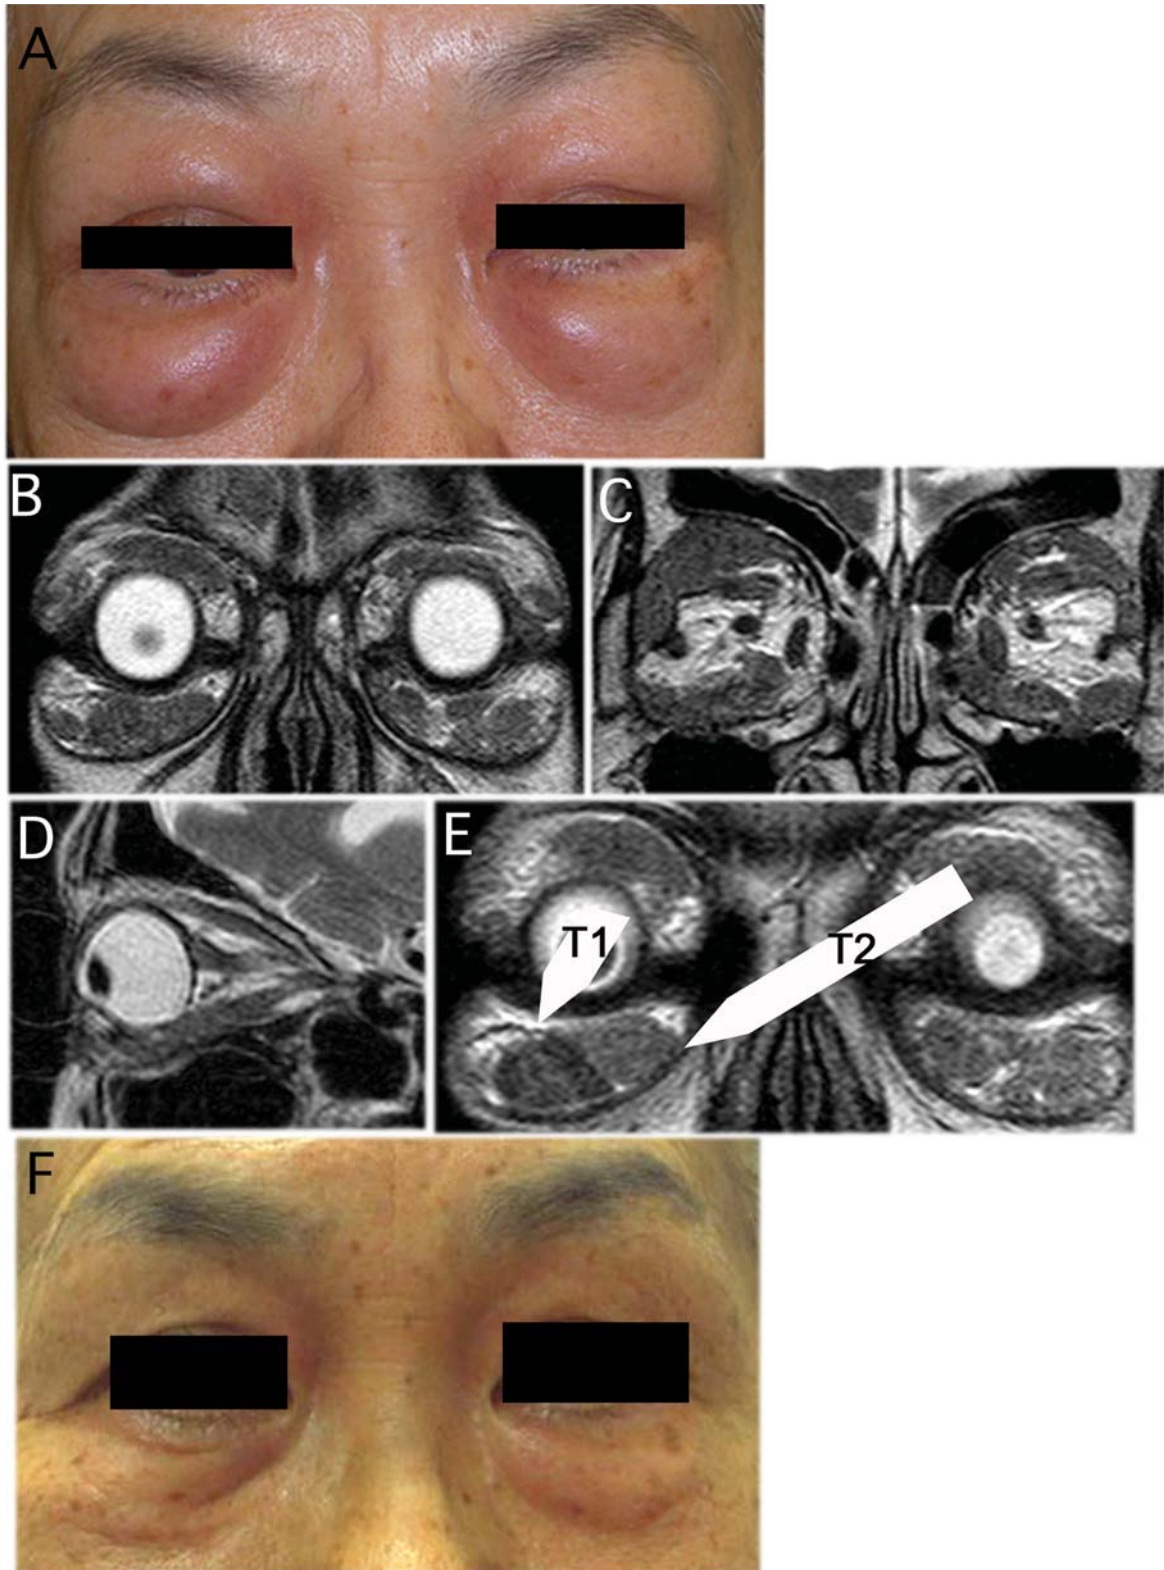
Facial photograph before and after treatment (A and F, respectively), and magnetic resonance imaging (MRI) at the initial presentation (B-E). A: The patient exhibits bilateral superior and inferior eyelid swelling without pain. B-D: T2-Weighted MRI demonstrates massive bilateral orbital lesions from the subcutaneous layer to deep orbit with a low density. E: There are two kinds of lesion, one presenting with a low density (tumor type 1, T1) and are with relatively high density (tumor type 2, T2). F: Eyelid swelling completely resolved after treatment.
